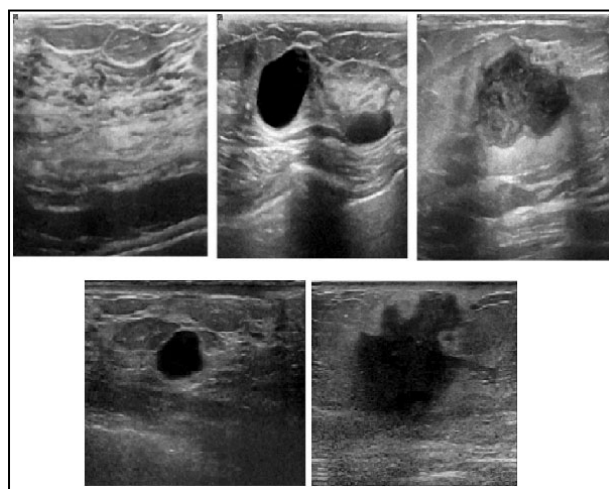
Ultrasound Image database samples.
